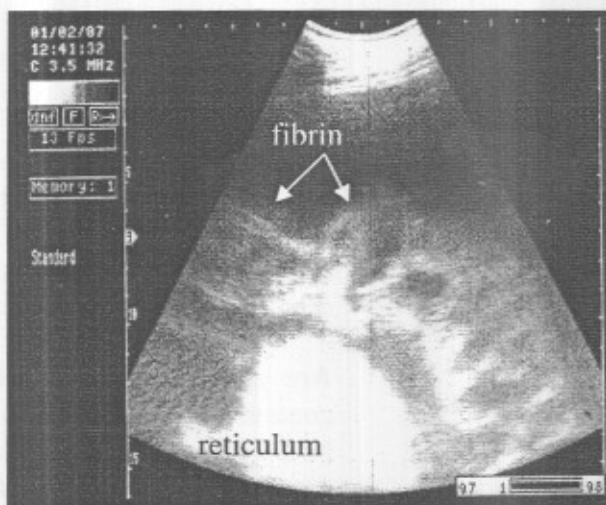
Ultrasonographic image shows large amount of echogenic debris and bands with hypoechoic exudates. Extend from xiphoid cartilage until the udder. Using 3.5 MHz sector probe.
